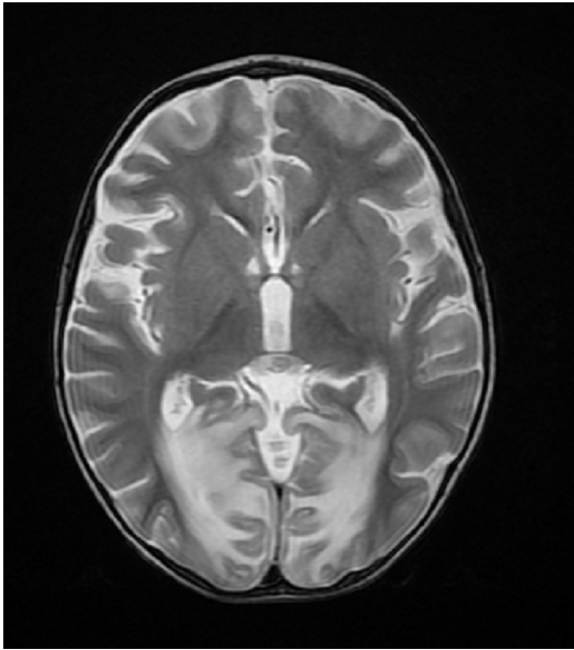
T2-weighted MRI scan of patient's brain: hyperintensity in the occipital and parietal lobes due to vasogenic edema.
